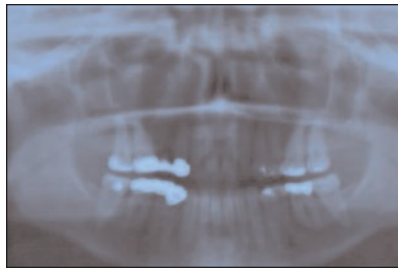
Pre-assessment panoramic radiograph
